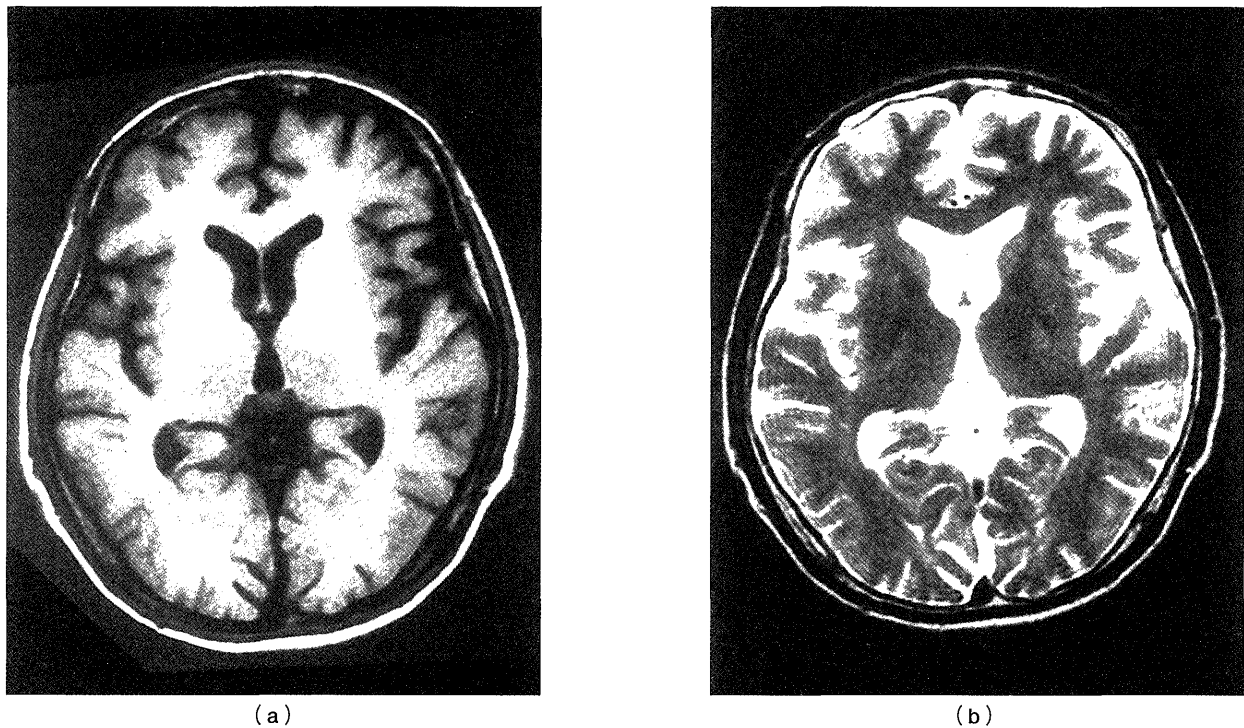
T1-weighted MRI of a cirrhotic patient revealed bilateral signal hyperintensity in the globus pallidus(a), but corresponding T2-weighted image for same patient was normal (b).
